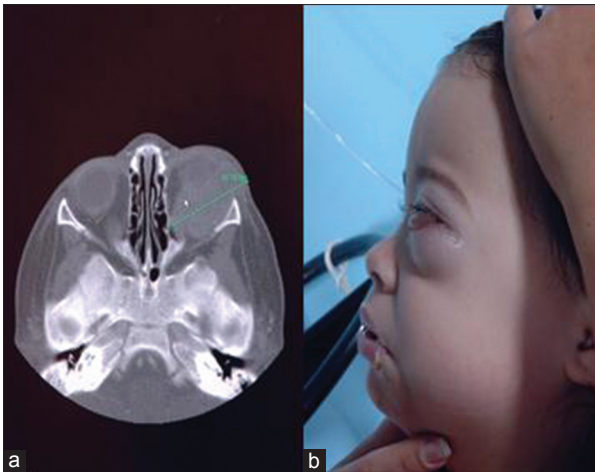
(a) The orbital Computed Tomography scan showing left retro-orbital mass. (b) Left eye proptosis at presentation (verbal permission was taken from the guardians)
